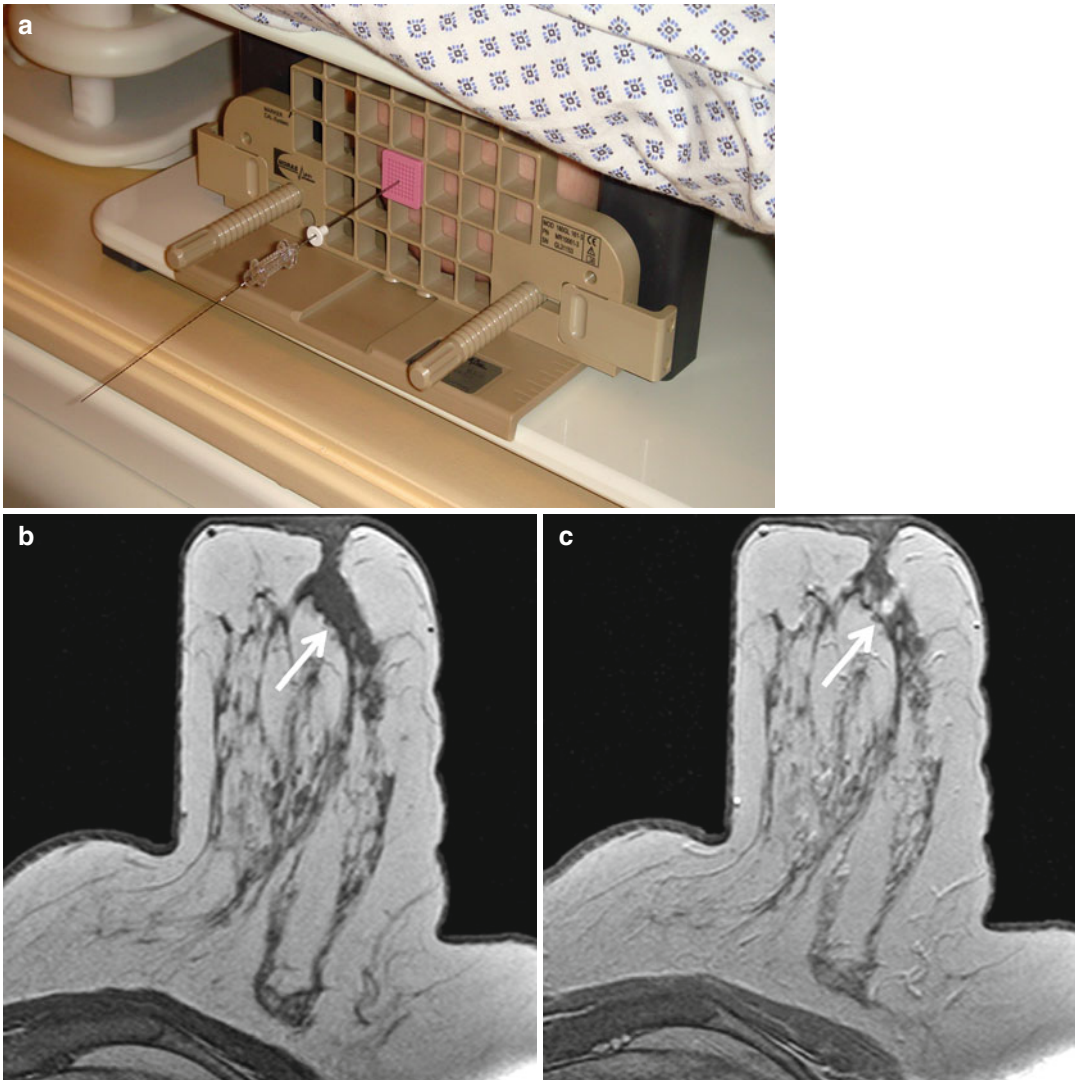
MR-guided needle localization. (a) Picture of needle guide and needle in place. (b–f) 56-year-old patient with biopsy proven breast cancer on the right breast. Preoperative breast MR imaging showed a suspicious focal (<5 mm) retromamillary lesion in the left breast. (b) T1-weighted gradient echo (TR/TE, 290/4.6; flip angle, 90°) before contrast and (c) first contrast enhanced, (d)
